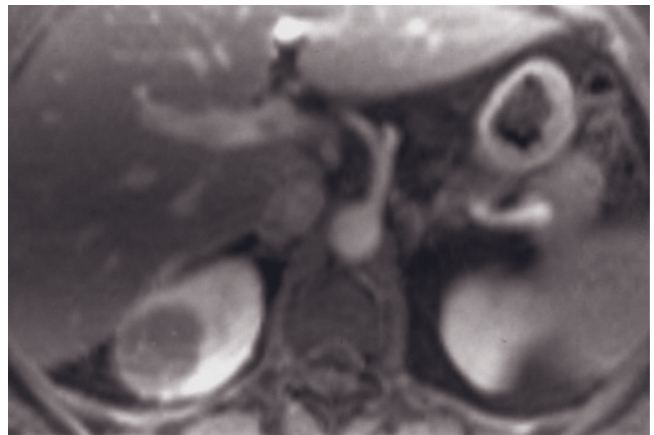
Primary small cell carcinoma of kidney and local recurrence. Coronal T2-weighted SS-ETSE (a), T1-weighted fat-suppressed gradient-echo (b), immediate postgadolinium T1-weighted gradient-echo (c), and interstitial-phase postgadolinium fat-suppressed gradient-echo (d) images. There is a large mass arising from the right kidney that demonstrates heterogeneous high signal intensity on T2-weighted image (a), low signal intensity on T1-weighted image (b), and mild heterogeneous enhancement on early (c)- and late (d)-phase images. At the periphery of the mass, there is a thin rim of enhancing cortex. T1-weighted gradient-echo (e) and interstitial-phase postgadolinium fat-suppressed 3D gradient-echo (f) images of the same patient 4 months after right nephrectomy demonstrate soft tissue implants near the medial margin of the liver (arrows, e, f), consistent with local recurrence. There is an additional focus of tumor that tracks along the liver capsule (arrowheads, e, f).
